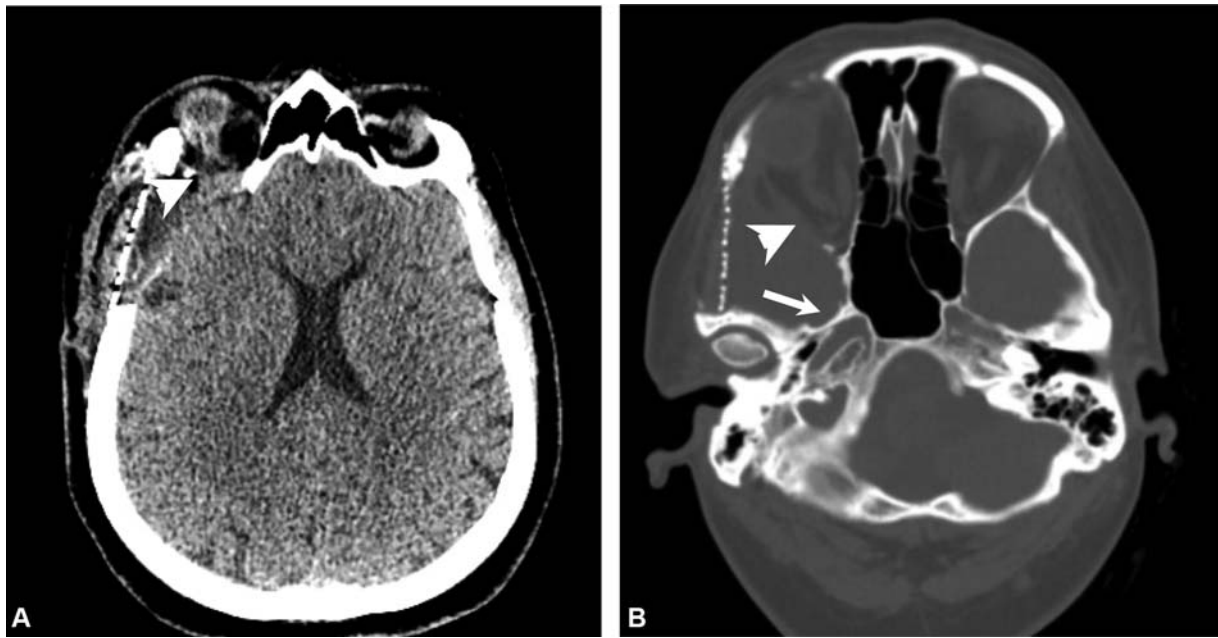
(A, B) Postoperative CT showing complete resection of all involved bone and dura with mesh was utilized for the cranioplasty. Note that no reconstruction was performed in the lateral orbital wall, aligning with the surgical goal of decompressing the orbit. This included all the bony lateral orbit posterior to the orbital rim (arrowhead) and the involved pterygoid bone (arrow). CT, computed tomography.
